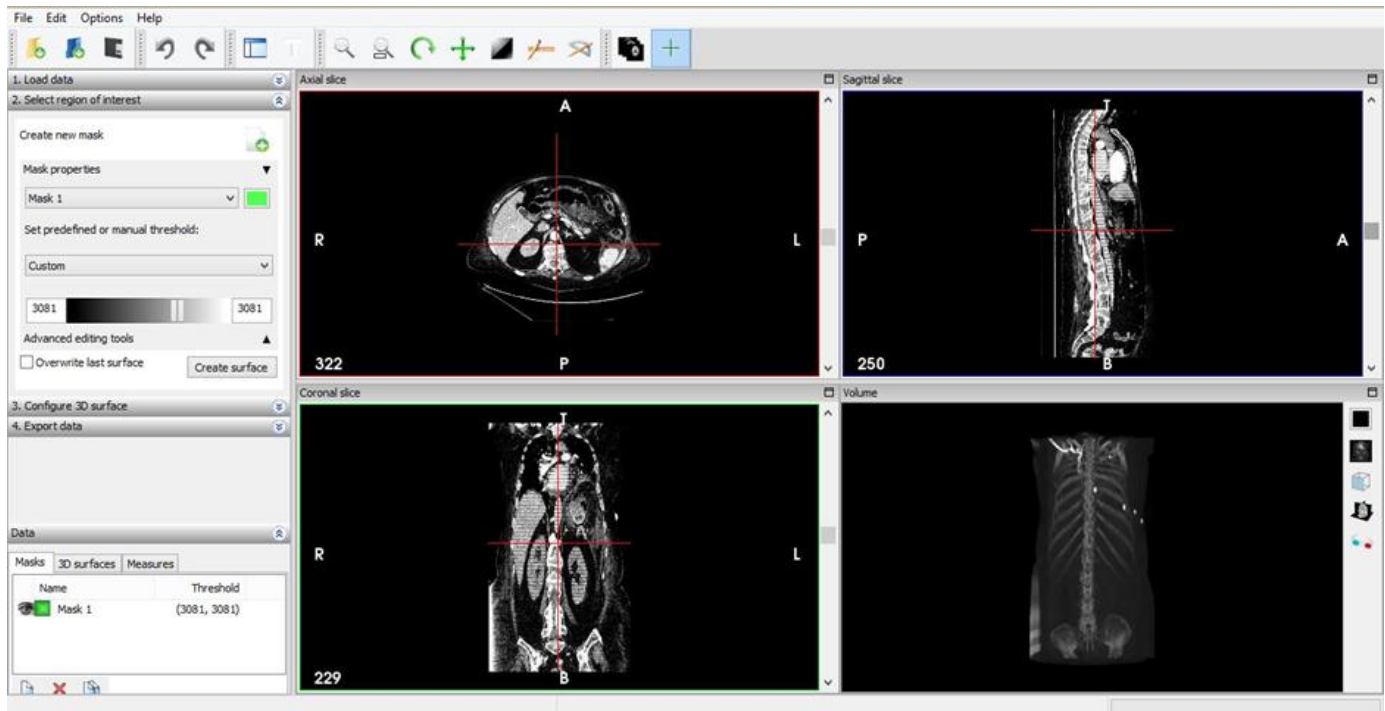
An example of MPR and VR from thorax CT with InVesalius.
